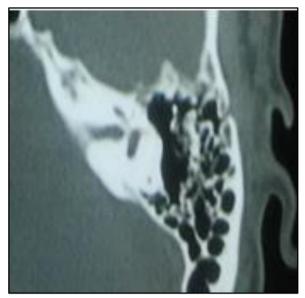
CT scan showing fracture of the Left Temporal Bone
